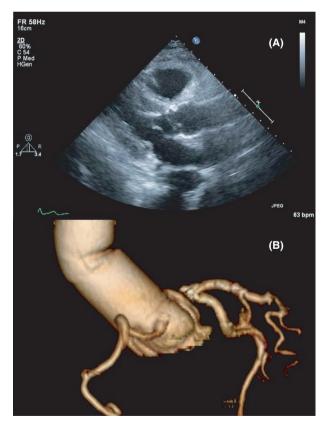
(A) Postoperative transthoracic echocardiography demonstrated normal aortic valve function. (B) Postoperative computed tomographic angiography shows the adequate shape of the neosinuses of Valsalva.
